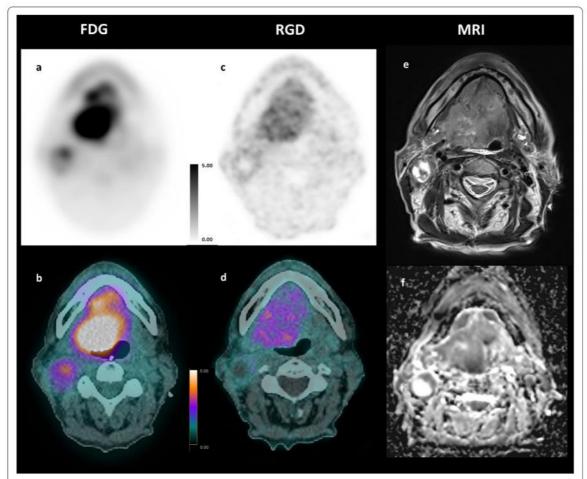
Comparative MRI, ¹⁸F-FDG, and ⁶⁸Ga-NODAGA-RGD PET/CT of patient #8. Axial PET/CT fusion slices of a 69-year-old man with a moderate differentiated base tong SCC. The images show different tumor-to-background ratios in between the two radiotracers ¹⁸F-FDG PET/CT (a, b) vs. ⁶⁸Ga-NODAGA-RGD PET/CT (c, d), and also a slightly different distribution of activity within the tumor bed when compared with the MR images e T2w and f ADC map of diffusion
